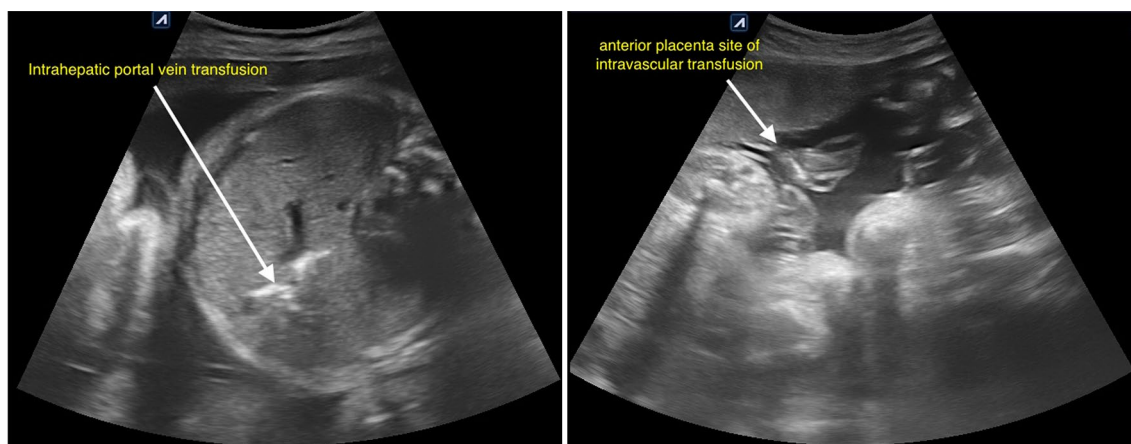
Case 1 ultrasound image of twin 1 undergoing intrahepatic portal vein transfusion and twin 2 with anterior placenta having placental cord insertion transfusion
